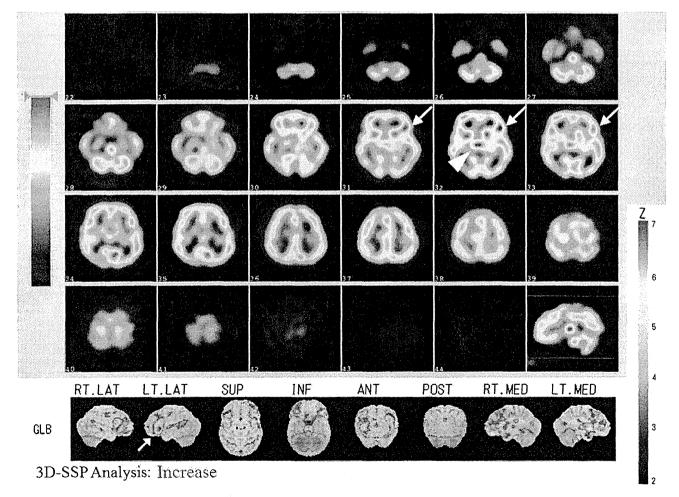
Ictal SPECT with I-123 IMP and 3D-SSP analysis. Ictal SPECT showed hyperperfusion in the left inferior frontal cortex (large arrow) and right thalamus (arrowhead). The 3D-SSP analysis emphasizes the hyperperfusion in the left inferior frontal cortex (small arrow).
